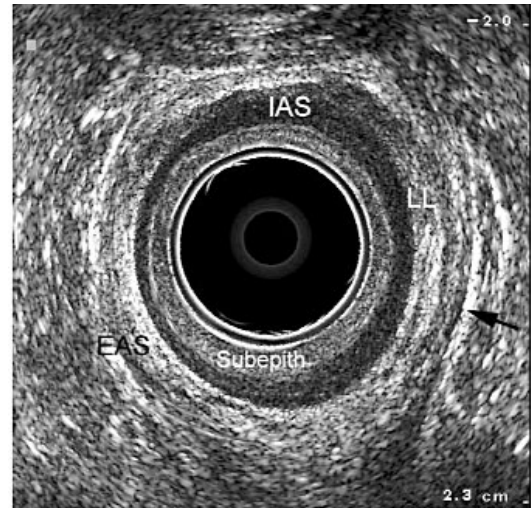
Axial endosonography in the mid canal in a normal 38yr old female. Subepith: subepithelial layer; IAS: internal anal sphincter; LL: longitudinal layer; EAS: external anal sphincter. The outer border of the external sphincter is defined by an interface reflection at the fat/muscle boundary (arrow).
